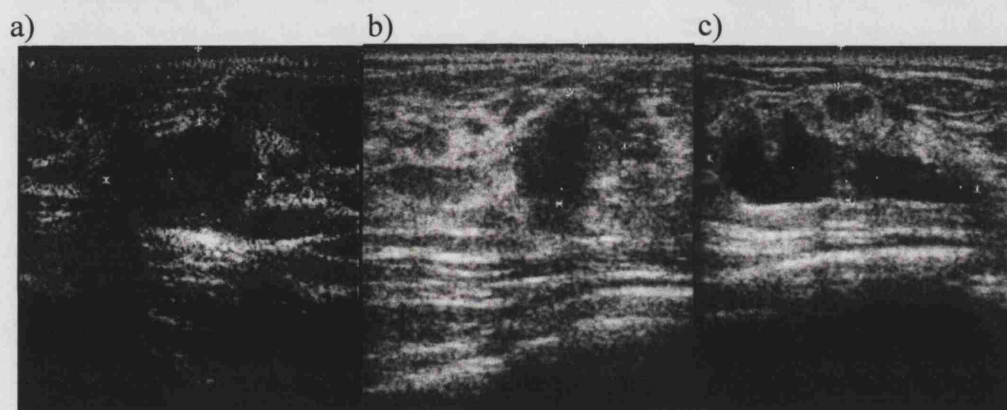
Ultrasound images of the breast in the region of the original lesion recorded a) one week before treatment b) three months after treatment and c) six months after treatment.
